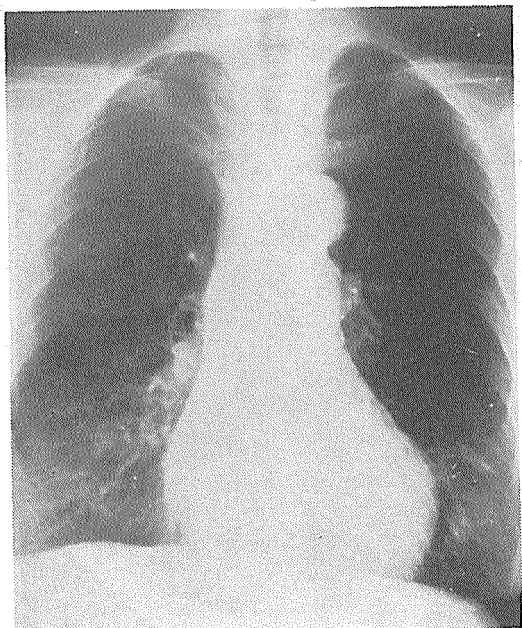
Lung X-ray in January 1991.
